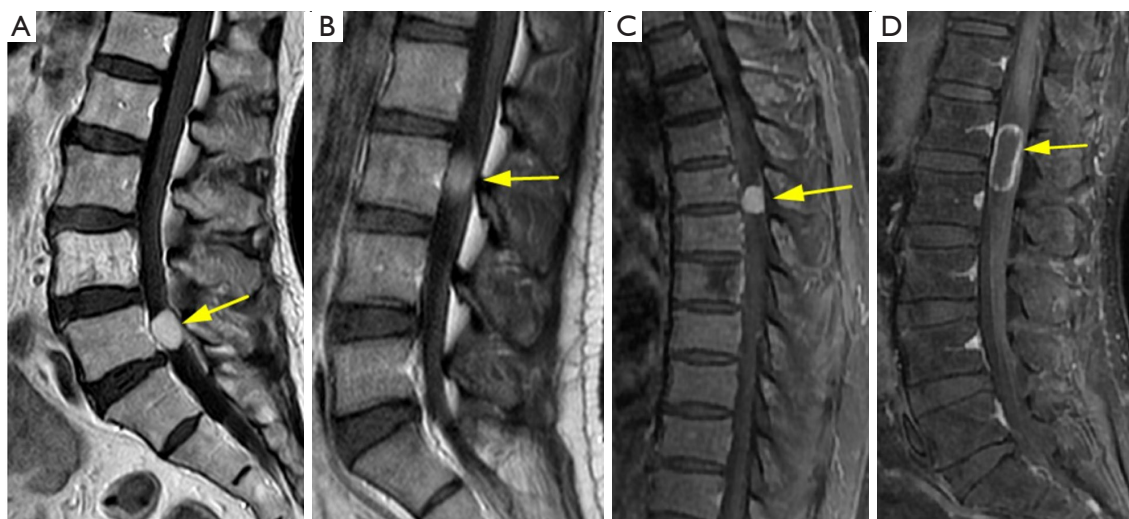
Examples of the degree and the pattern of enhancement for sagittal images of T1WI after contrast agent injection (the yellow arrows indicate the location of the tumors). (A,B) Enhancement degree: (A) strong, (B) moderate. (C,D) Enhancement pattern: (C) diffuse, (D) rim. T1WI, T1-weighted images.
